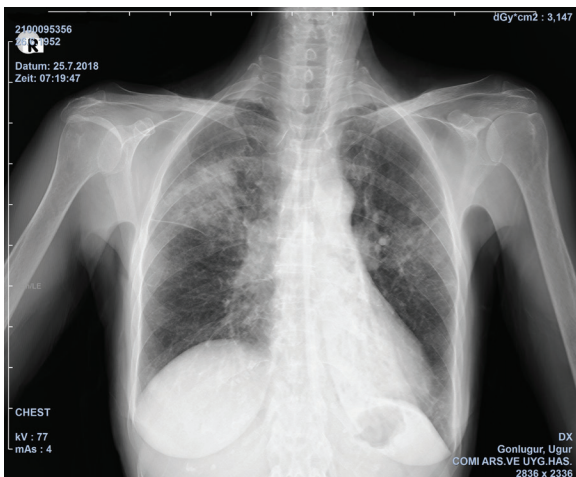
Chest x-ray shows bilateral infiltrates and double-contour of the left cardiac border.
